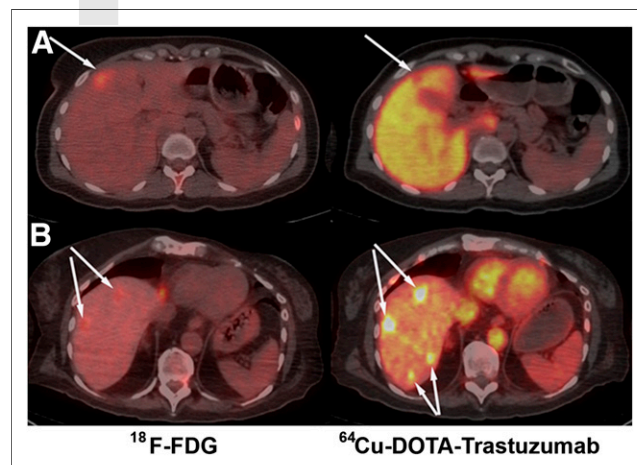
Visualization of hepatic metastases. (A) Fused transaxial PET/CT images of ¹⁸F-FDG and ⁶⁴Cu-DOTA-trastuzumab 21 h after injection for patient (patient A) given 5 mg of trastuzumab. Upper intensity thresholds (white color) correspond to SUV = 10 g/mL for ¹⁸F-FDG and 40 g/mL for ⁶⁴Cu-DOTA-trastuzumab. (B) Fused transaxial PET/CT images of ¹⁸F-FDG and ⁶⁴Cu-DOTA-trastuzumab 47 h after injection for patient (patient B) given 50 mg of trastuzumab. Upper intensity thresholds correspond to SUV = 10 g/mL. Arrows indicate detected lesions. For patient A, anterior hepatic lesion is visualized as cold spot on ⁶⁴Cu-DOTA-trastuzumab scan. Liver SUV was 27.6 g/mL in patient A, compared with 5.5 g/mL in patient B, for whom hepatic lesions are dramatically visualized as hot spots. For patient B, 2 lesions not seen with ¹⁸F-FDG are detected with ⁶⁴Cu-DOTA-trastuzumab.
